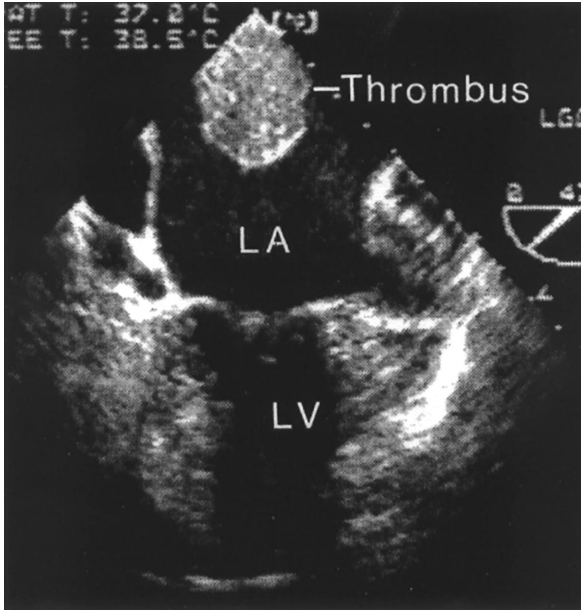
Transesophageal echocardiogram showing a large left atrial thrombus. LA = Left atrium; LV = left ventricle.
